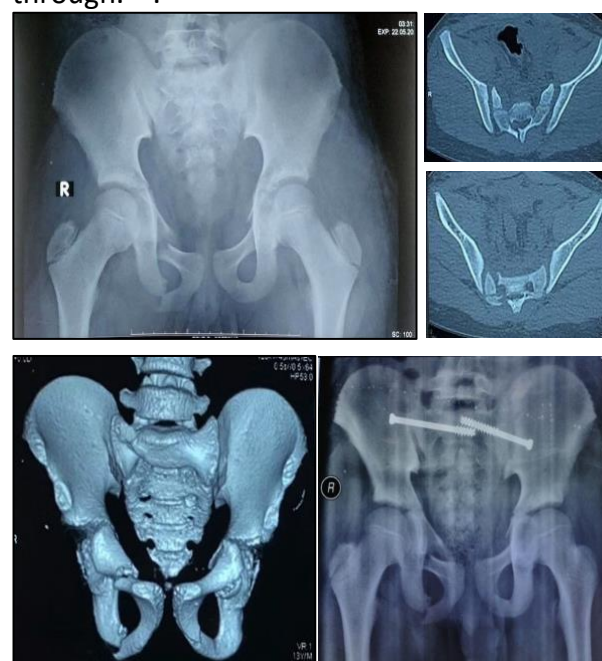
Children, 13 years old with left sacroiliac joint disruption, right sacral fracture and pubic rami fracture (a) initial x-ray; (b & c) CT Scan showing right transforaminal sacral fracture and disruption of left SI Joint; (d) postoperative x-ray after percutaneous screwing
